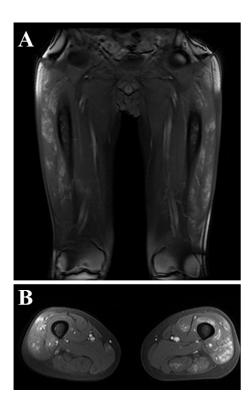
MRI findings of the lower limb muscles. (A) Coronal section. (B) Horizontal section.
